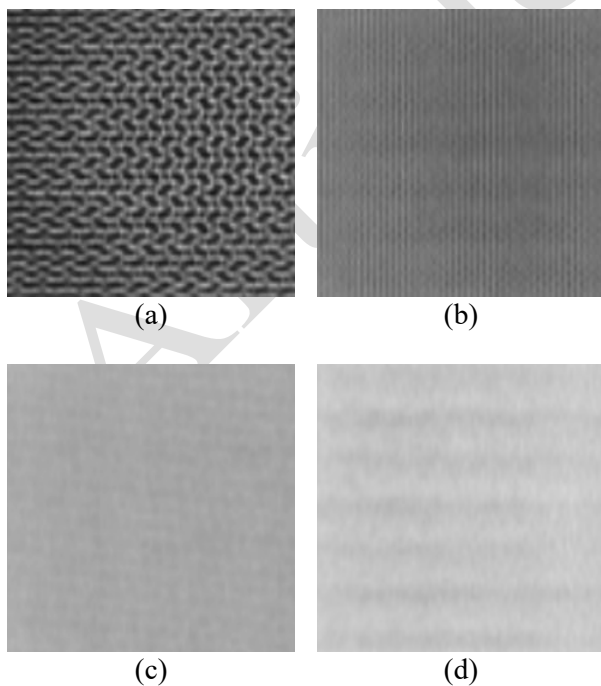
CT images of infill layer within the plate-shaped 3D-printed HIPS boluses at infill densities of (a) 20%, (b) 40%, (c) 60%, and (d) 80%.
